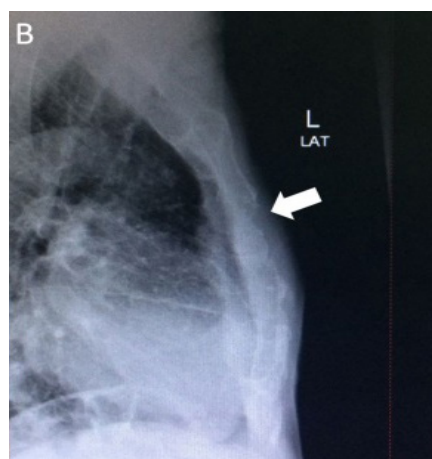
Chest radiograph from lateral view showing abnormal cortical outlines of the sternum (white arrow)
